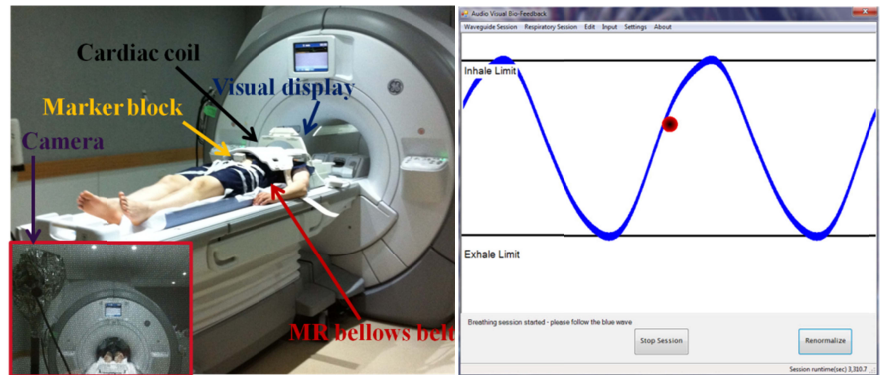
(left) Audiovisual biofeedback system in 3T MRI. Infrared camera and marker block on the abdomen. (right) Audiovisual respiratory waveguide (blue curve) with real-time abdominal position (red ball).
